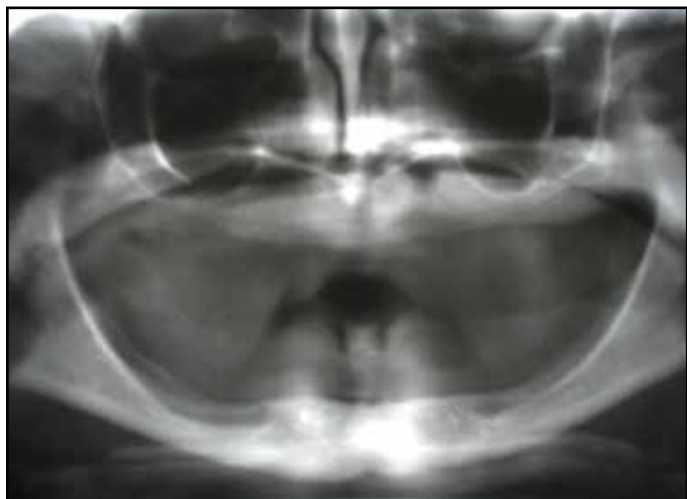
Pre-op radiograph of female patient.
